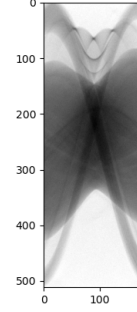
Corrected CT sinogram
